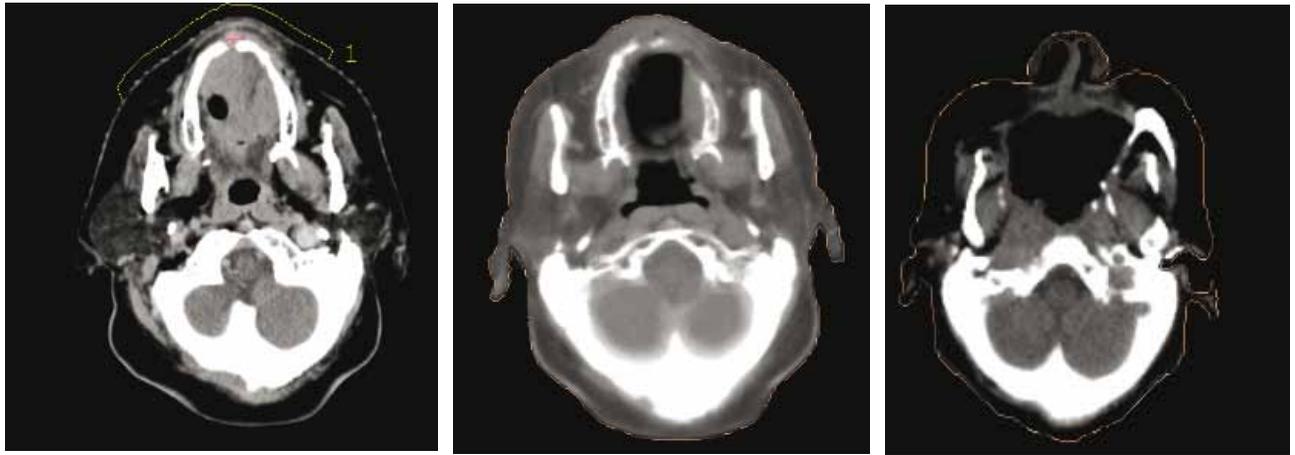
From the left: CT for hard palate tumor at presentation, middle CT after radiation therapy showing maximum response after end of radiotherapy, right: CT after 3 months of maxillectomy with tumor recurrence at the right wing of sphenoid bone.
